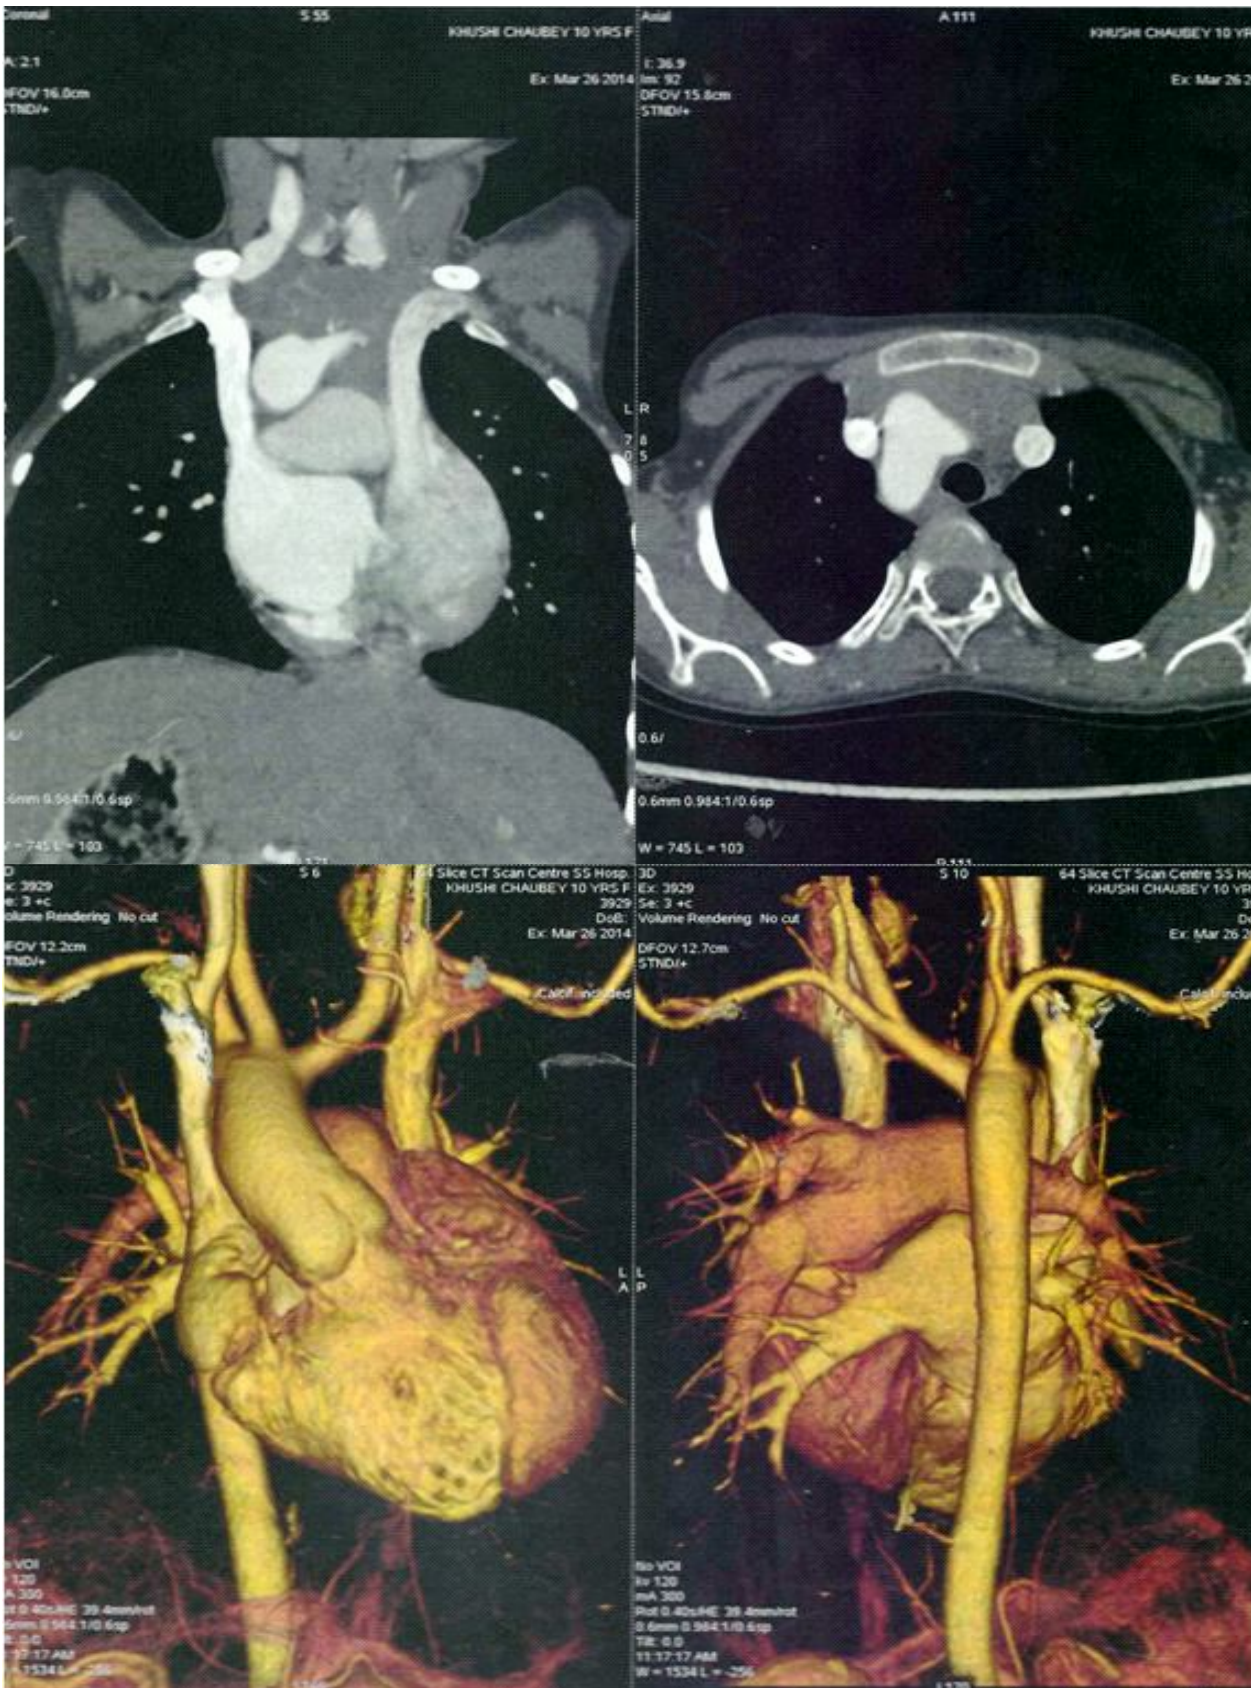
A,B,C,D: Contrast enhanced CT images coronal (A), Axial (B) showing right and left superior vena cava but no innominate vein (C, D). Left superior vena cava is draining into coronary sinus
